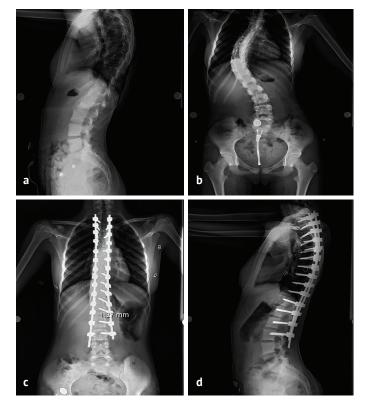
(a) Exemplary X-ray AP images of the patient before the surgical procedure, (b) exemplary X-ray lateral images of the patient before the surgical procedure, (c) exemplary X-ray AP images of the patient after the surgical procedure, (d) exemplary X-ray lateral images of the patient after the surgical procedure AP: Anteroposterior
